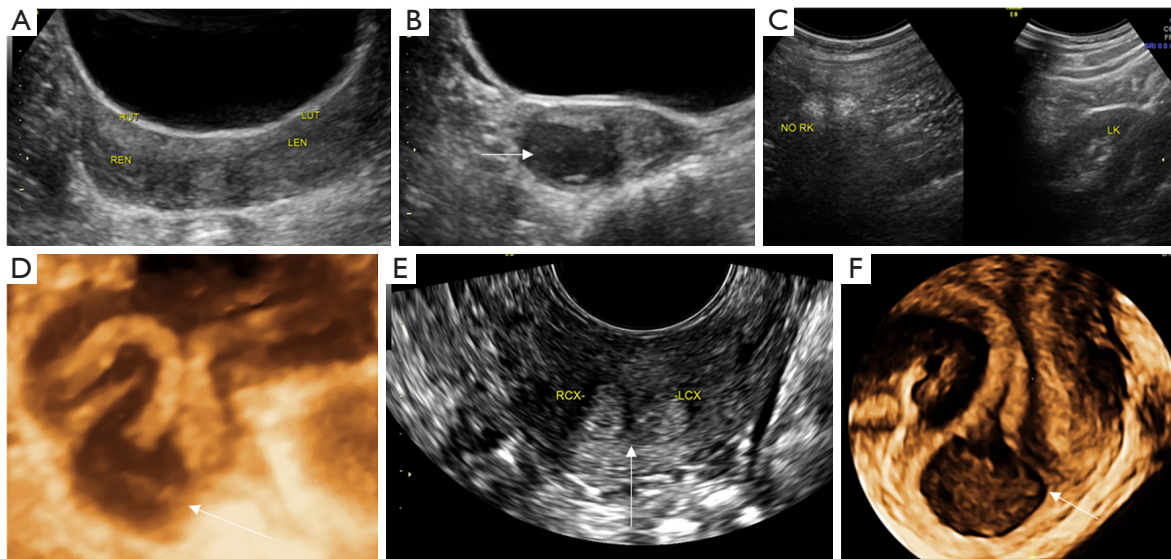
Type I-c UGTOIRA syndrome: U3b-C1-high OVS, complete bicorporal uterus, septate cervix without cervical obstruction, with right-high OVS (with a foramen on the OVS observed intraoperatively), and right renal agenesis. Sonograms were obtained from a 17-year-old female patient. (A) TAS 2D coronal pelvic plane demonstrating the complete bicorporal uterus and septate cervix. (B) TAS 2D cross-section of the lower part of the cervix demonstrating OVS with a small amount of hematocoele in the posterior space of the OVS (the arrow indicates the blood accumulation). (C) TAS 2D sagittal planes identifying the absence of the right kidney (NO RK; left side of the figure) and a normal left kidney (LK; right side of the figure). (D) TAS 3D coronal plane of the uterus-cervix-vagina under stereoscopy demonstrating the complete bicorporal uterus, septate cervix, and high OVS with a small amount of hematocoele in the posterior space of the OVS (the arrow indicates the OVS). (E) TRS 2D cross-section of the cervix demonstrating the cervical septate (the arrow indicates the cervical septate). (F) TRS 3D coronal planes of the cervix-vagina under stereoscopy demonstrating the septate cervix and high OVS with a small amount of hematocoele in the posterior space of the OVS (the arrow indicates the OVS). RUT, right uterus; LUT, left uterus; REN, right endometrium; LEN, left endometrium; RK, right kidney; LK, left kidney; RCX, right cervix; LCX, left cervix; UGTOIRA, unilateral genital tract obstruction with ipsilateral renal anomaly; OVS, oblique vaginal septum; TAS, transabdominal sonography; TRS, transrectal sonography; 2D, 2-dimensional; 3D, 3-dimensional.
